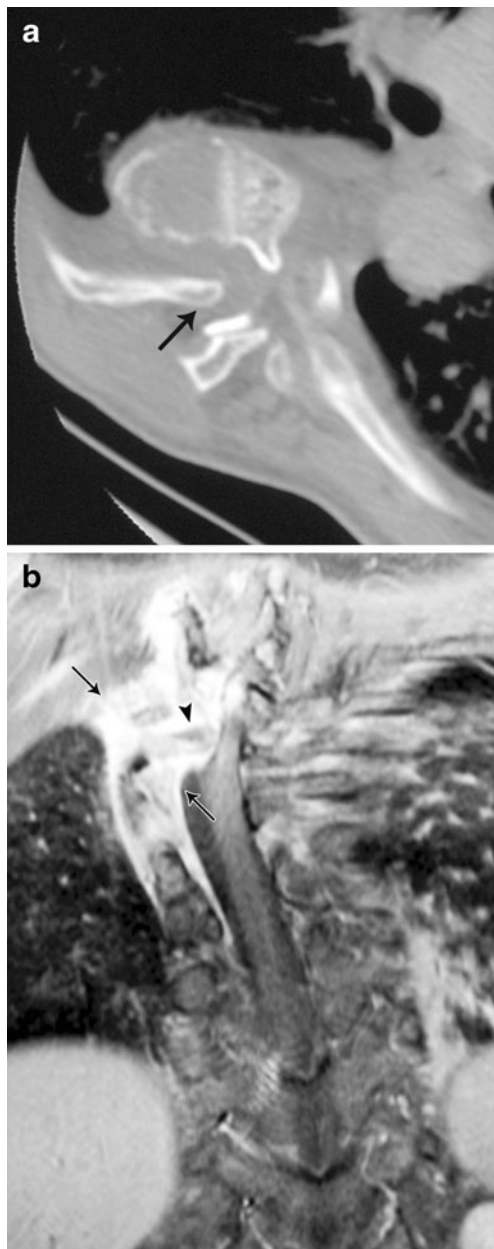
Case 4. a Axial CT shows widening of the neural foramina with intraspinal displacement of the right sixth rib head (*black arrow*). Linear ossific density to the right of the displaced rib head represents the superior articulating facet of the lower vertebrae. b Coronal T1-W post-contrast MRI reveals an enhancing right paraspinal neurofibroma (*arrows*) extending into the spinal canal at the apex of the curve. There is displacement of the cord to the left by the dislocated right sixth rib head (*arrowhead*)
